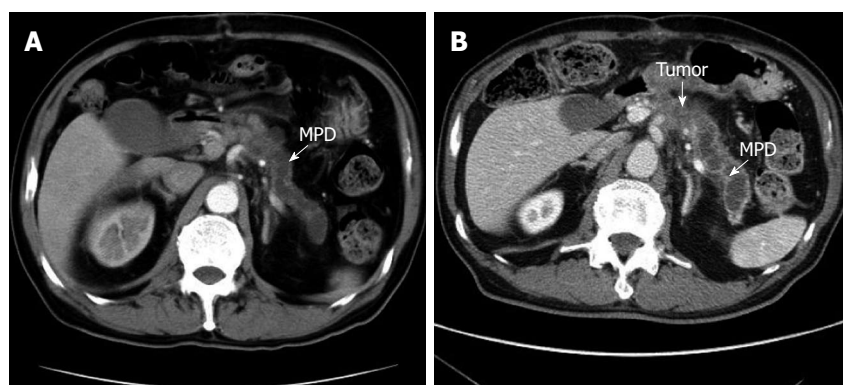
Computed tomography scan demonstrating the dilatation of the main pancreatic duct (A) and a tumor of the pancreatic body which invaded the celiac artery after the abdominal aortic aneurysm operation (B). MPD: Main pancreatic duct.
